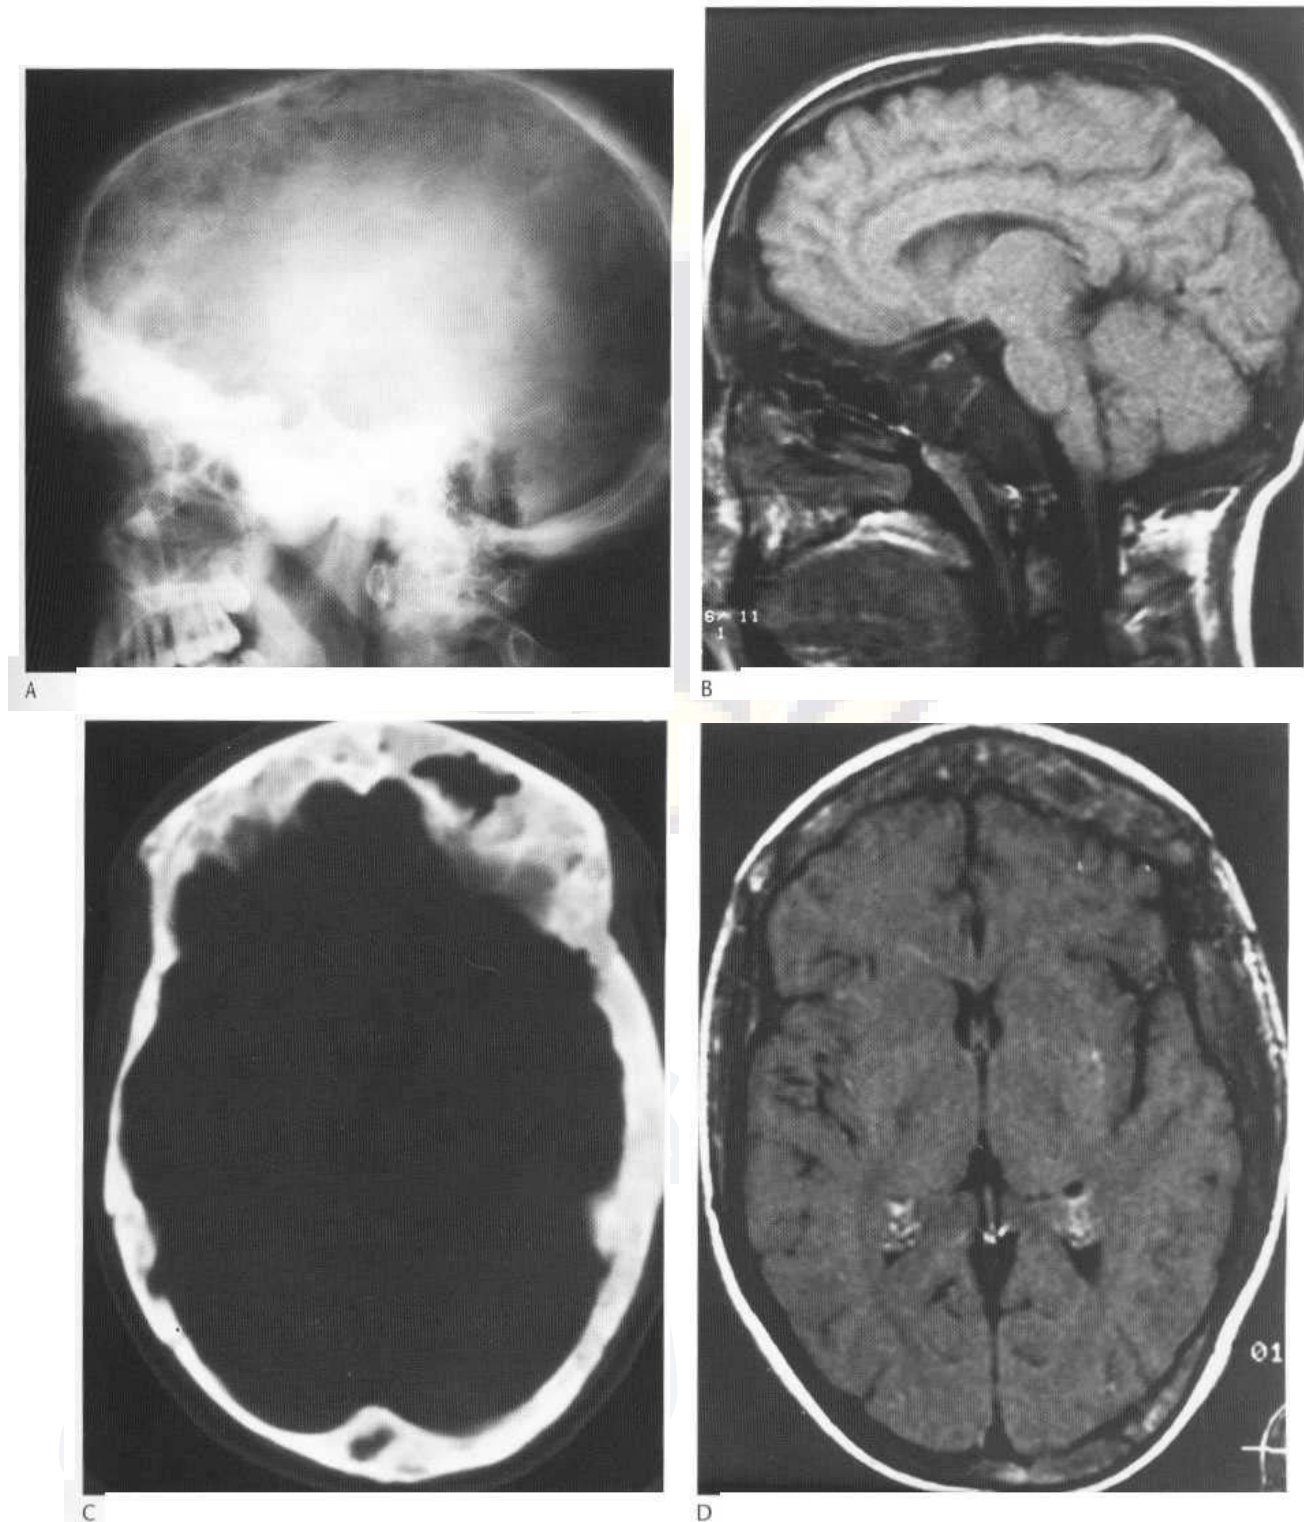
Polyostotic fibrous dysplasia. (A) The plain film shows extensive involvement of the skull base which is sclerotic and thickened, but a rather more patchy and diffuse involvement of the vault, which shows areas of normal bone interspersed with areas of thickened bone. (B) On the sagittal T₁-weighted MR sequence the appearances exactly mirror the changes seen on the plain film. The skull base is thickened and shows extensive low signal with loss of marrow. Marrow is only to be seen in part of the frontal bone. The region of the frontal sinus, which is obliterated, shows a mixture of low and intermediate signal. The low signal indicates mineralisation, the intermediate fibrous tissue, and the subcutaneous fat shows uniform bright signal. (C) An axial CT scan through the vault shows a typical mixed pattern of fibrous tissue which is partially mineralised. Cysts are shown. (D) The same skull at MR imaging. On the T₁-weighted sequence the bright outer band represents fat beneath the skin; the thickened skull vault is seen as a mainly low-signal area anteriorly.
